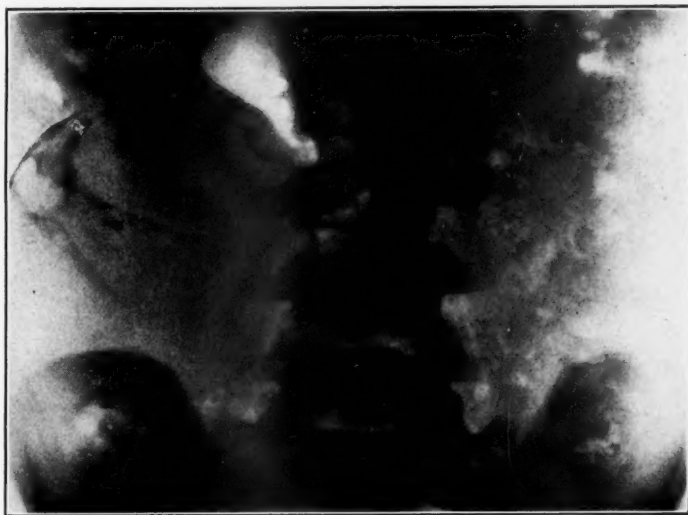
Roentgenogram of tumor before operation. Opaque substance containing rudimentary mandible and teeth can be outlined.
